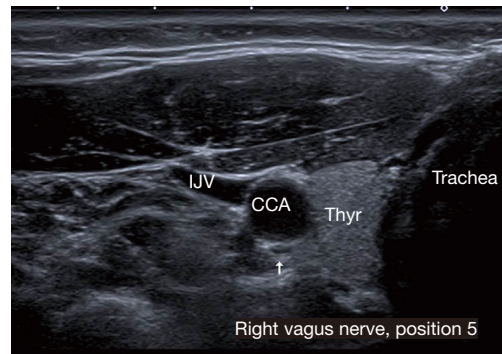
Ultrasound aspect of the right vagus nerve (white arrow) in position 5. THYR, thyroid lobe; IJV, internal jugular vein; CCA, common carotid artery.
